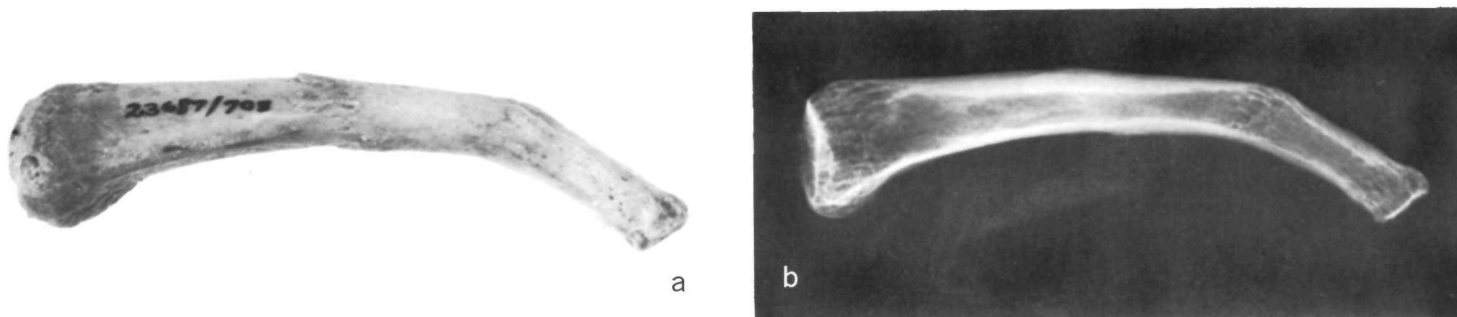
a, Congenital fusion of three phalanges of the small finger, left hand (23687/703); b, roentgenogram of the same phalanges.
